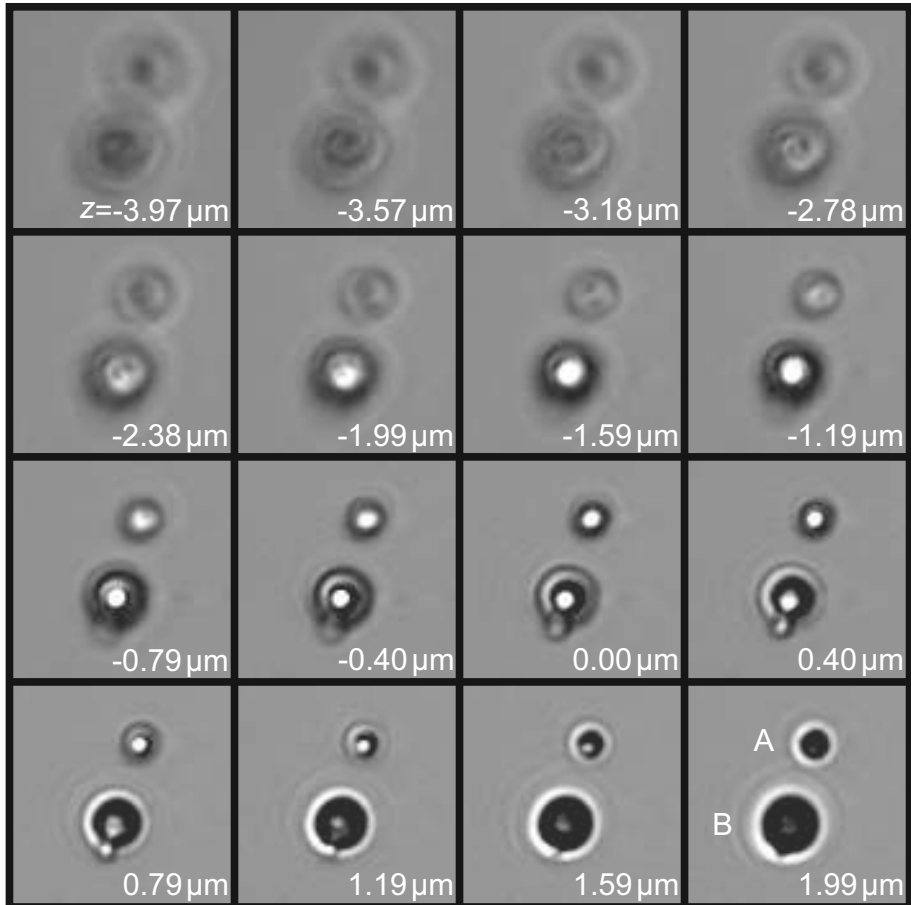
$z$ -stack of two ultrasound contrast agent microbubbles. Proximal-to-focus Airy disks can be seen around the bubbles, whereas distal-to-focus the bubble boundaries are blurred. Microbubble A has a diameter of  $2\ \mu\text{m}$ , whereas microbubble B has a diameter of  $3\ \mu\text{m}$ . Each frame corresponds to a  $11 \times 11\ (\mu\text{m})^2$  area.
